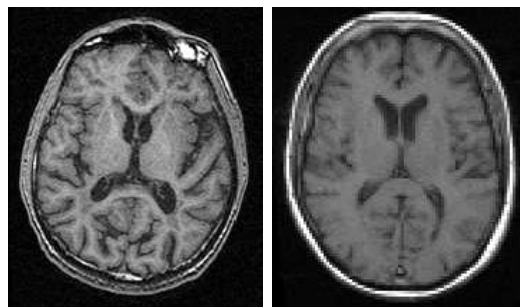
A typical T1-weighted MR image with good contrast between brain GM, WM and CSF (left) versus a T1 image from our data set (right).
